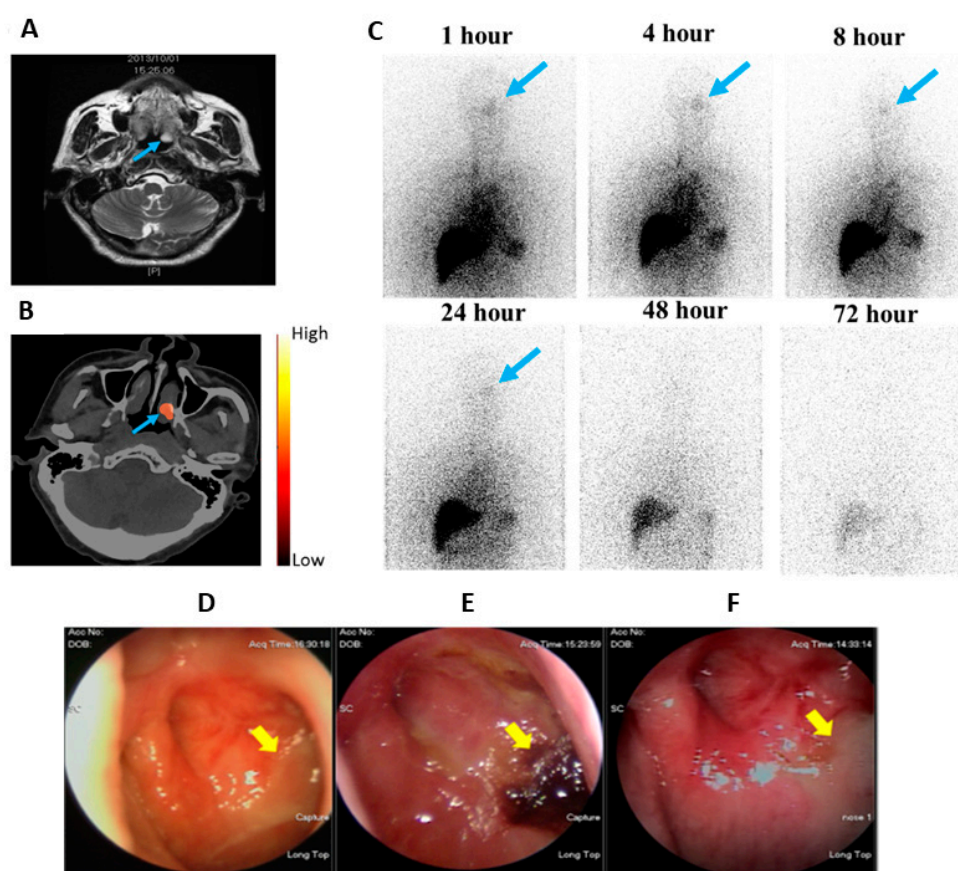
Phase 0 clinical studies of ^{188}Re -liposome SPECT/CT imaging showing tumor targeting and uptake in a NPC patient (Pt. 14) with pulmonary and mediastinal metastasis: (A) One month before ^{188}Re -liposome injection, MRI shows there is a soft tissue lesion (blue arrow) in the left nasopharynx, (B) SPECT/CT 24 h after ^{188}Re -liposome injection as seen on the MRI, (C) Anterior upper-body images at six different time points after ^{188}Re -liposome injection (blue arrows indicate the lesion over the left nasopharynx), (D) The nasopharyngoscopic examination one month before ^{188}Re -liposome injection shows the left nasopharyngeal mass with a crust and mucoid (yellow arrow), (E) Two months after ^{188}Re -liposome injection, there are engorged blood vessels and irregular surface over the left nasopharynx (yellow arrow) and (F) One year after the trial, the nasopharyngoscopic study shows fibrosis over the left nasopharynx (yellow arrow). Figures adapted with permission from [29].
